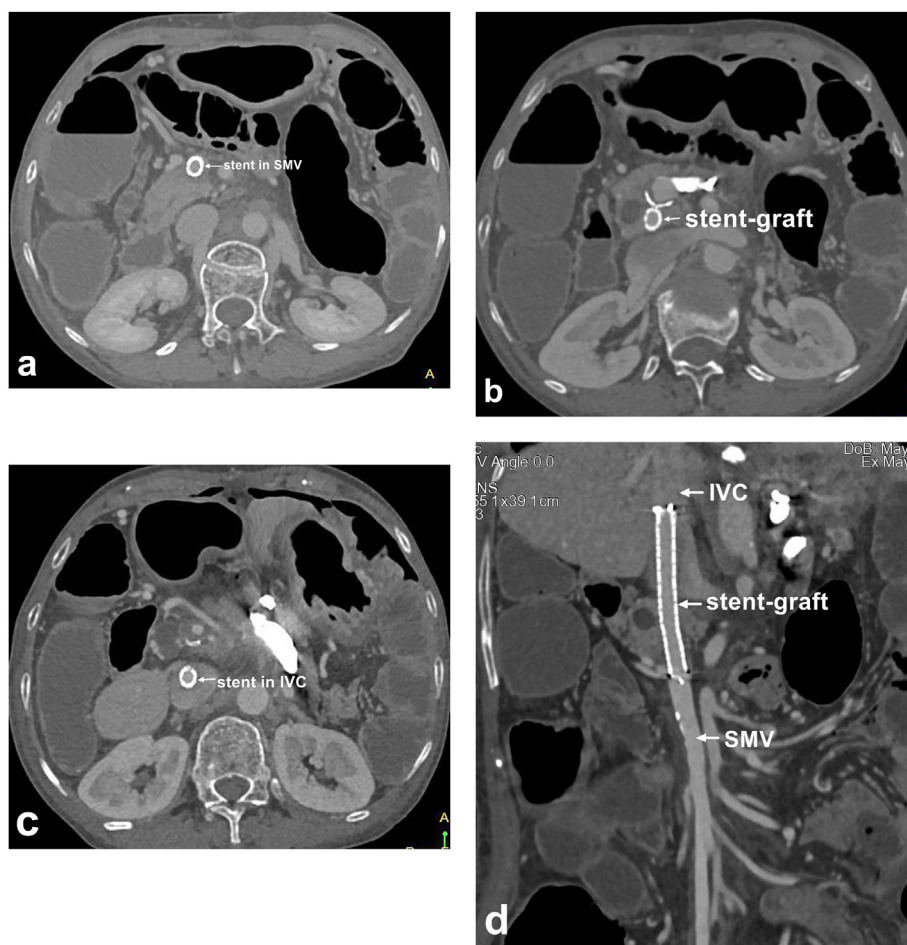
Postoperative computed tomographic venography. (a) The distal end of the covered stent graft was in the superior mesenteric vein (SMV). (b) The middle segment of the covered stent graft was in the gap between the inferior vena cava (IVC) and superior mesenteric vein (SMV). No hematoma was noted around the stent graft. (c) The proximal end of the stent graft was in the IVC. (d) The SMV and the stent graft were patent.
